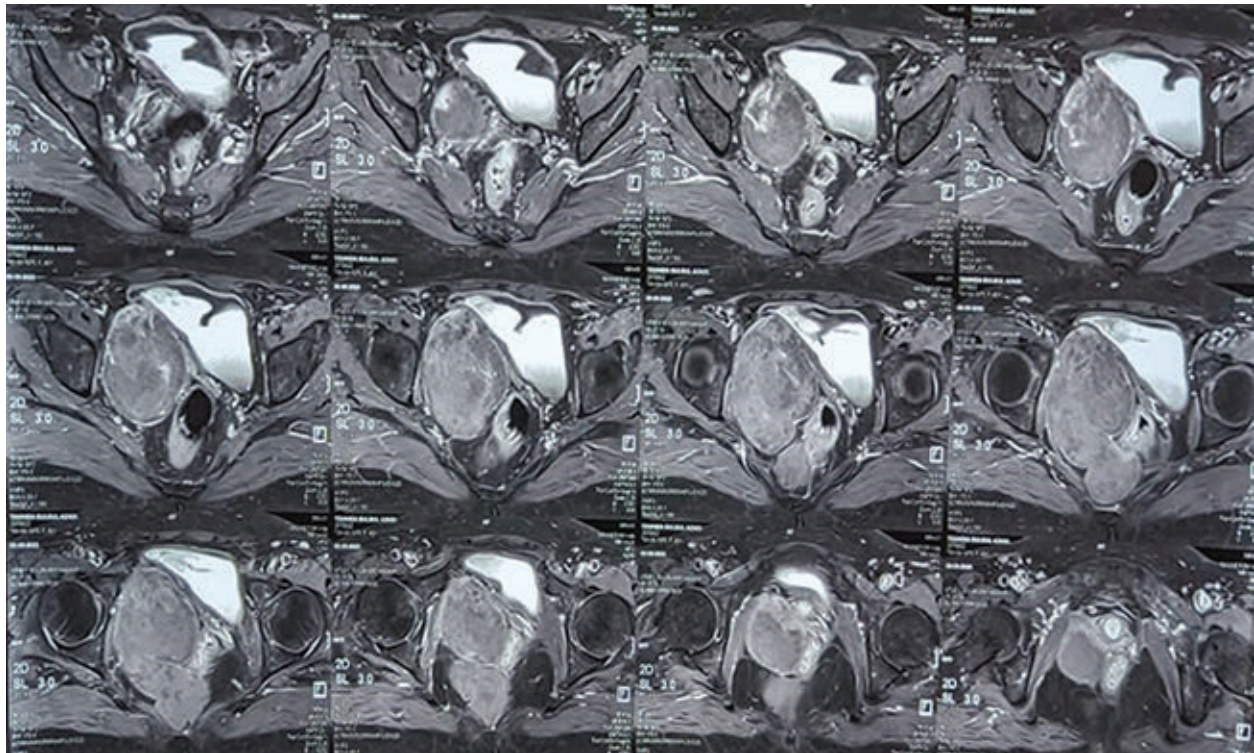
MRI showing Hemorrhagic cyst (12x7x7cm) at the right adnexa with extension into right perianal compression over rectum and urinary bladder.
